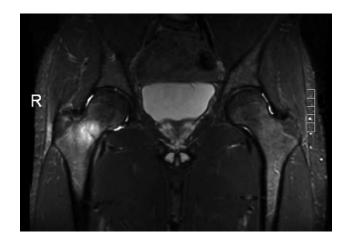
Magnetic resonance imaging demonstrating bone edema and an incomplete stress fracture on the compression side of the right femoral neck. Anterior view. R: right
